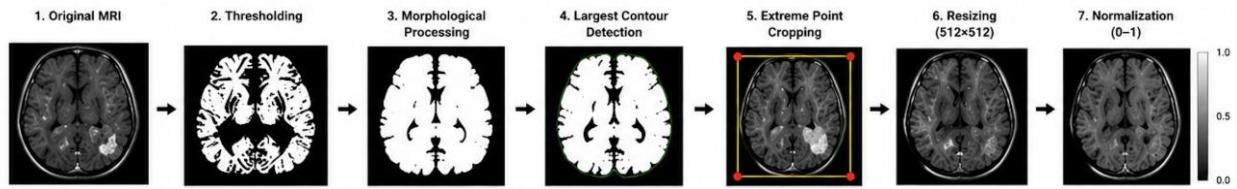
Representative MRI preprocessing and tumour-region extraction
